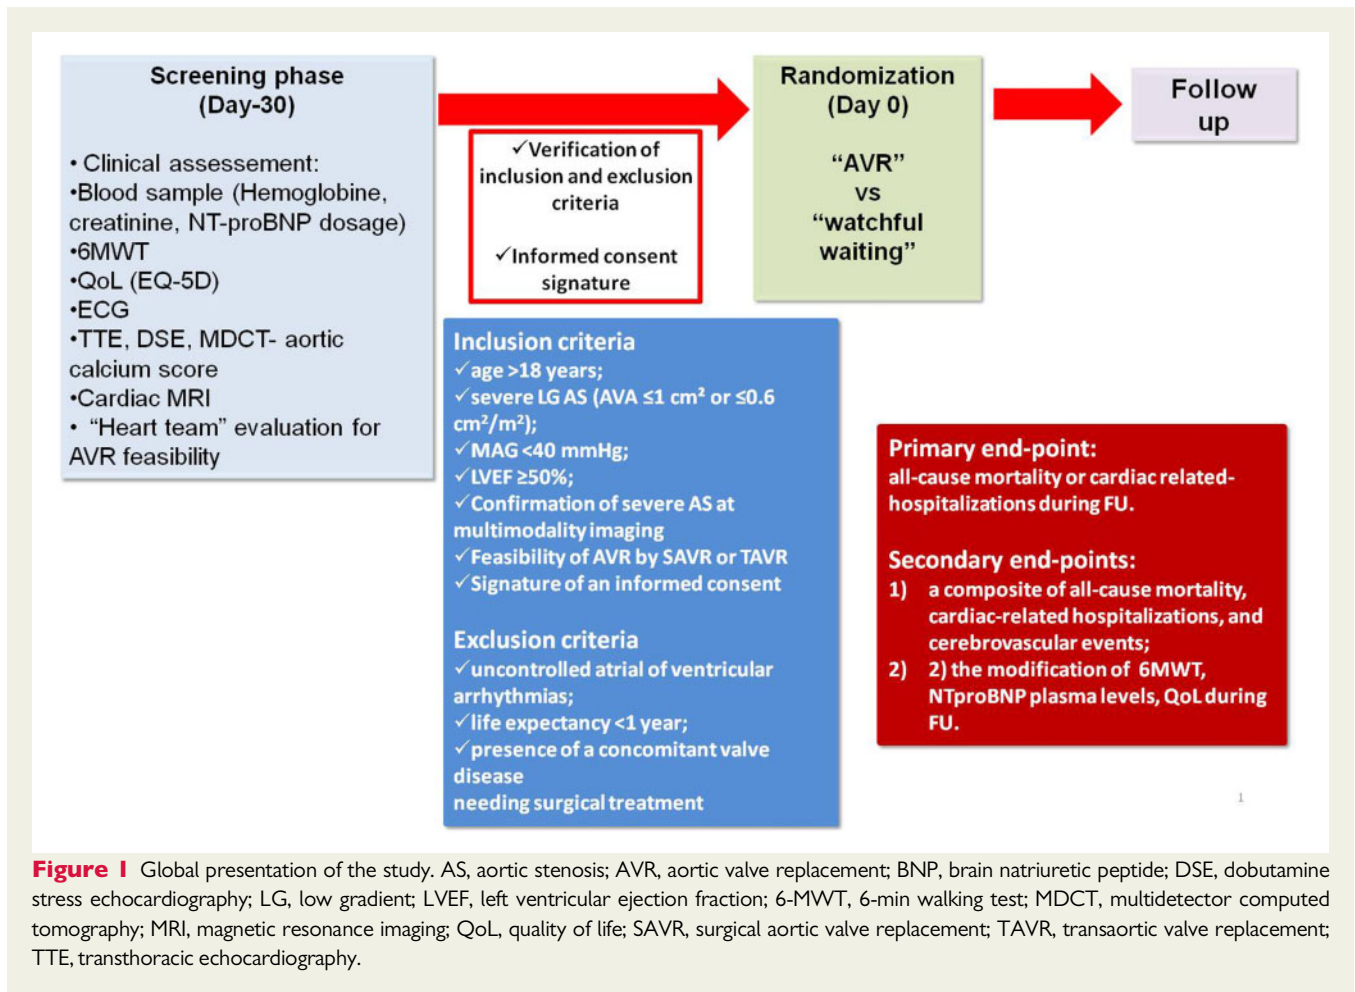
Global presentation of the study. AS, aortic stenosis; AVR, aortic valve replacement; BNP, brain natriuretic peptide; DSE, dobutamine stress echocardiography; LG, low gradient; LVEF, left ventricular ejection fraction; 6-MWT, 6-min walking test; MDCT, multidetector computed tomography; MRI, magnetic resonance imaging; QoL, quality of life; SAVR, surgical aortic valve replacement; TAVR, transaortic valve replacement; TTE, transthoracic echocardiography.
